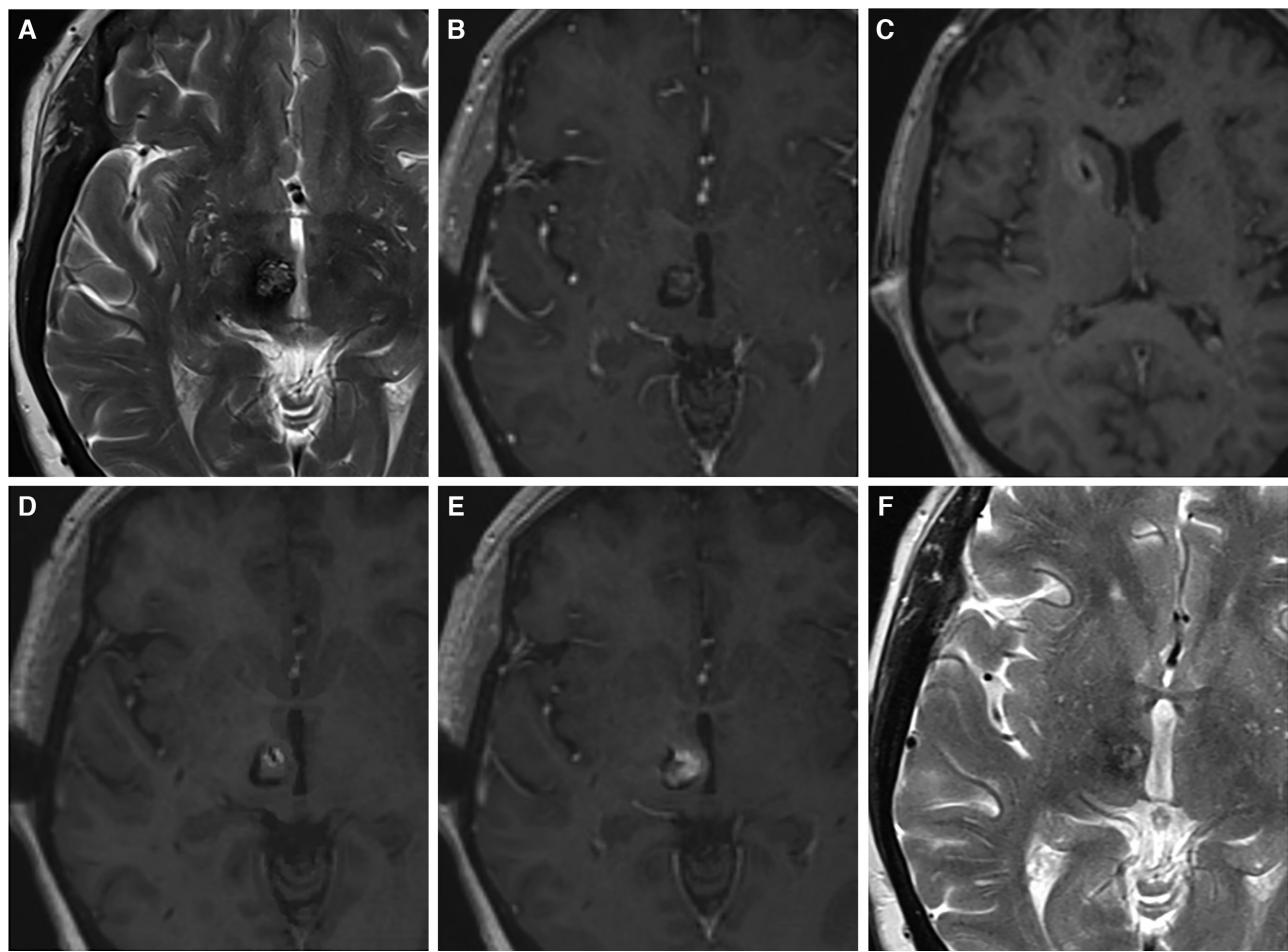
Ablation of CCM of posterior right subthalamus in patient 4. A, Preoperative axial T2-weighted image showing the mixed-intensity lesion prior to ablation. B, Intraoperative gadolinium-enhanced T1-weighted image showing lesion pre-ablation. C, Intraoperative contrast-enhanced T1 showing a small subcaudate tract hemorrhage (high intensity) around the cannula (low intensity). D, Intraoperative axial T1-weighted image immediately following first medial ablation (high intensity) around the cannula (low intensity). E, Intraoperative axial T1-weighted image showing lesion immediately following a second more lateral ablation. Note the difference in cannula position within the lesion and increased medial contrast enhancement. F, Follow-up axial T2-weighted image at 4.5 mo showing partial involution.
